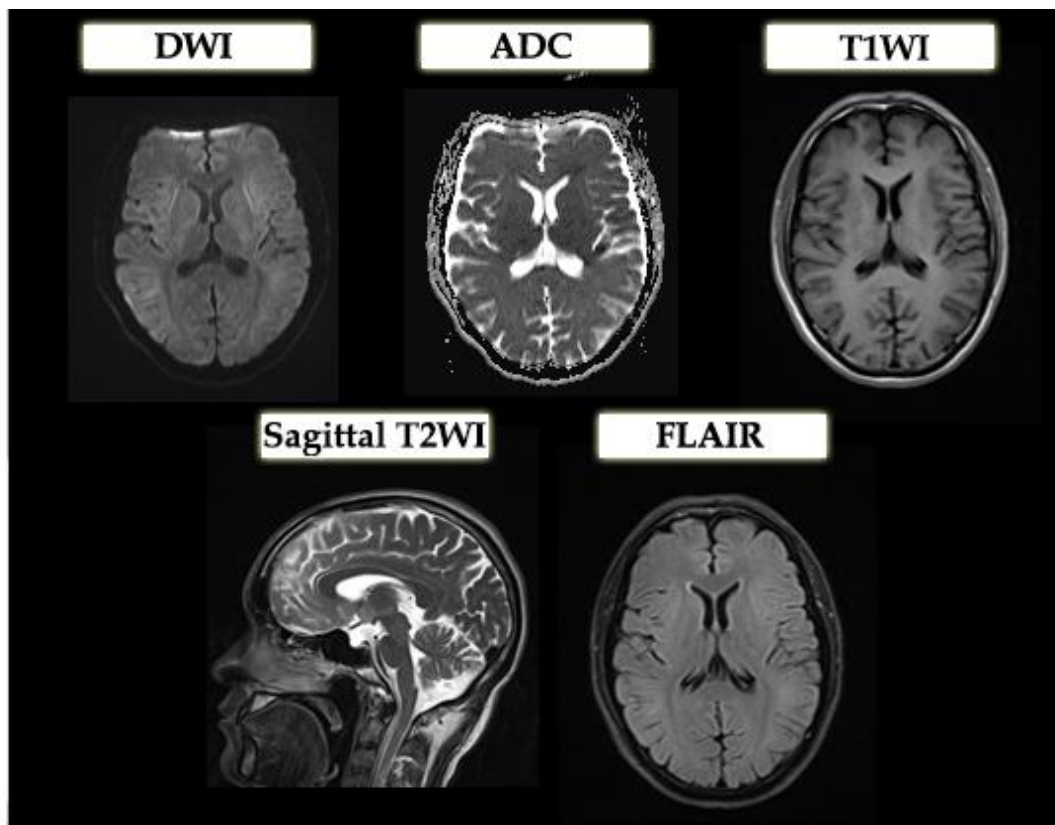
Patient's imaging studies after three months of treatment; MRI shows great improvement compared to admission 3 months ago. MRI demonstrates decreased bilateral symmetrical abnormal signal in subcortical U-fibers, corticospinal tract (including internal and external capsules), and cerebellar dentate nucleus. MRI revealed no abnormal signals in cerebral grey matter, periventricular white matter, corona radiata, brain stem, and cerebellar hemispheres.
